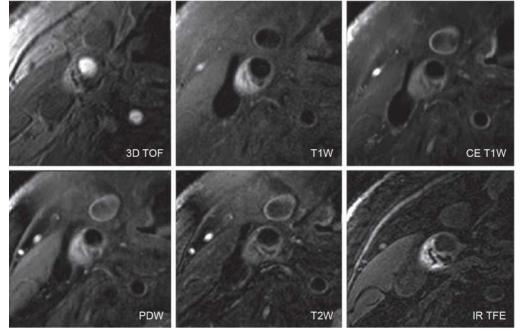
Hyperintense signal in the plaque is due to intraplaque hemorrhage on the three-dimensional time-of-flight (3D TOF), T1-weighted (T1W), and inversion recovery turbo field-echo (IR TFE) sequences. Hypointense signals in both TOF and IR TFE techniques are the densely calcified areas. (Modified from Chu B, Ferguson MS, Chen H, et al: Cardiac magnetic resonance features of the disruption-prone and the disrupted carotid plaque. JACC Cardiovasc Imaging 2:883, 2009.)
